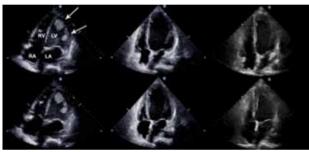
Serial transthoracic echocardiograms (right atrium, RA; left atrium, LA; right ventricle, RV, left ventricle LV), during diastole (top) and systole (bottom) on presentation (left, LV ejection fraction (EF) 5%), after 29 days (mid, LV EF 27%) and 4 months (right, LV EF 45%). Please note large LV thrombi (arrows).
